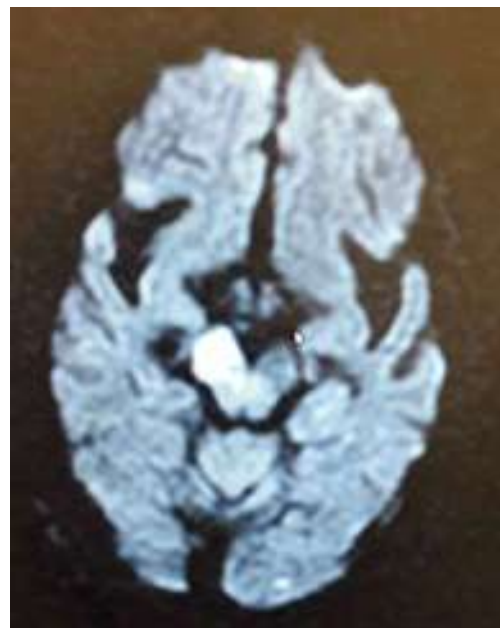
Showing Right MCA infarct in the repeat MRI
